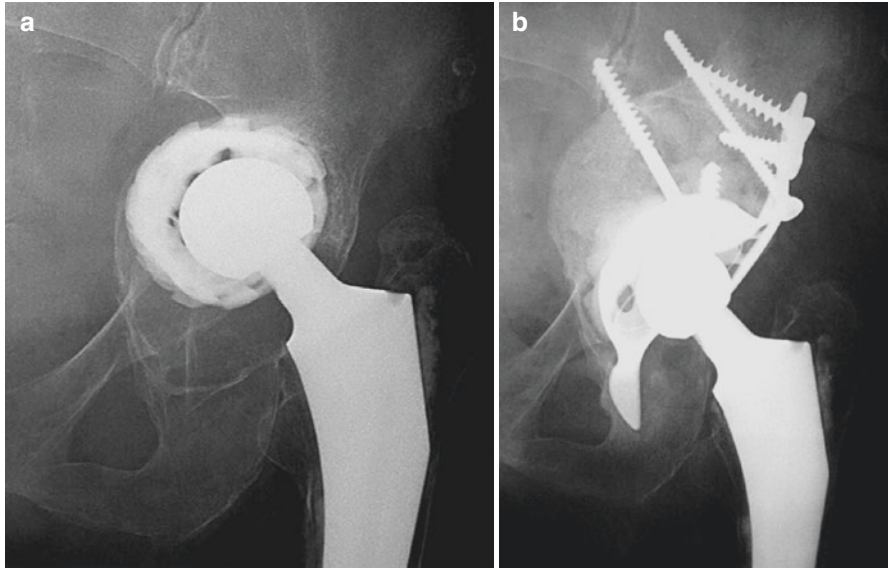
(a) Anteroposterior radiograph showing a failed THA with pelvic discontinuity in a 72 year-old man, 12 years after surgery. (b) 5 years after revision with BSAC and morcellised bone allograft
